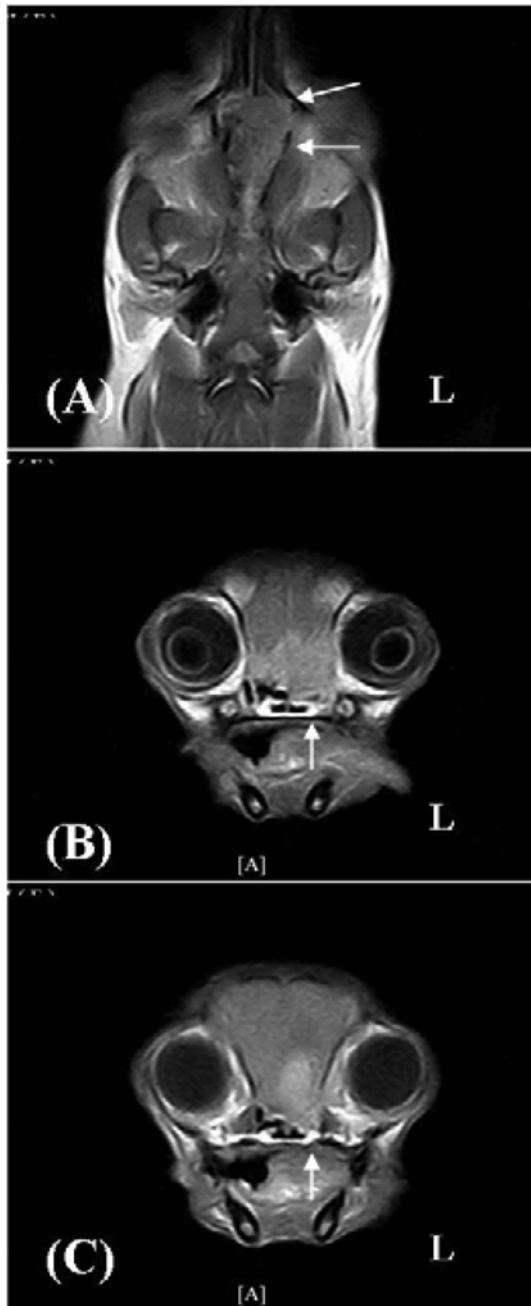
Post-contrast T1-weighted MR images. Post-contrast T1-weighted dorsal plane image (A) and post-contrast T1-weighted transverse images (B and C). A: The mass in the left nasal cavity and invading of the nasal septum are readily seen in this image (arrow). However, there is no evidence to encroach onto the cribriform plate in this image. B and C: There is a presence of contrast enhanced mass involving the rostral left brain. The left sphenopalatine sinus is destructed by the mass. This lesion shows the presence of invading of the cribriform plate.
